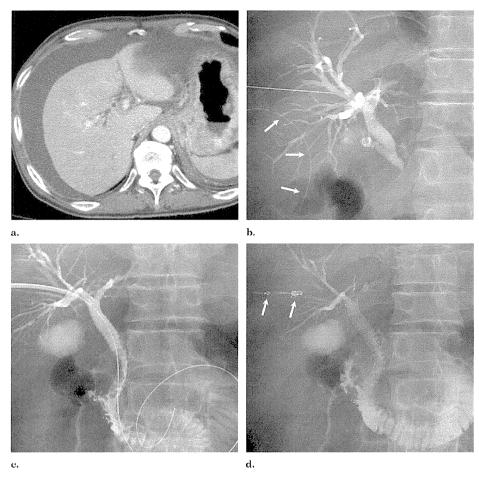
Gastric cancer with nodal metastasis in a 65-year-old man (patient 6; Table 1). (a) Contrast-enhanced CT before stent placement shows dilated intrahepatic biliary ducts and massive ascites. (b) Percutaneous transhepatic cholangiography reveals tight stricture at the distal common bile duct. Note that a 6-F tube was placed around the liver surface (arrows). (c) Cholangiography performed after stent placement shows good expansion of the stent and good flow of contrast material through the stent. (d) Embolization of the transhepatic tract was performed with metallic coils (arrows).
